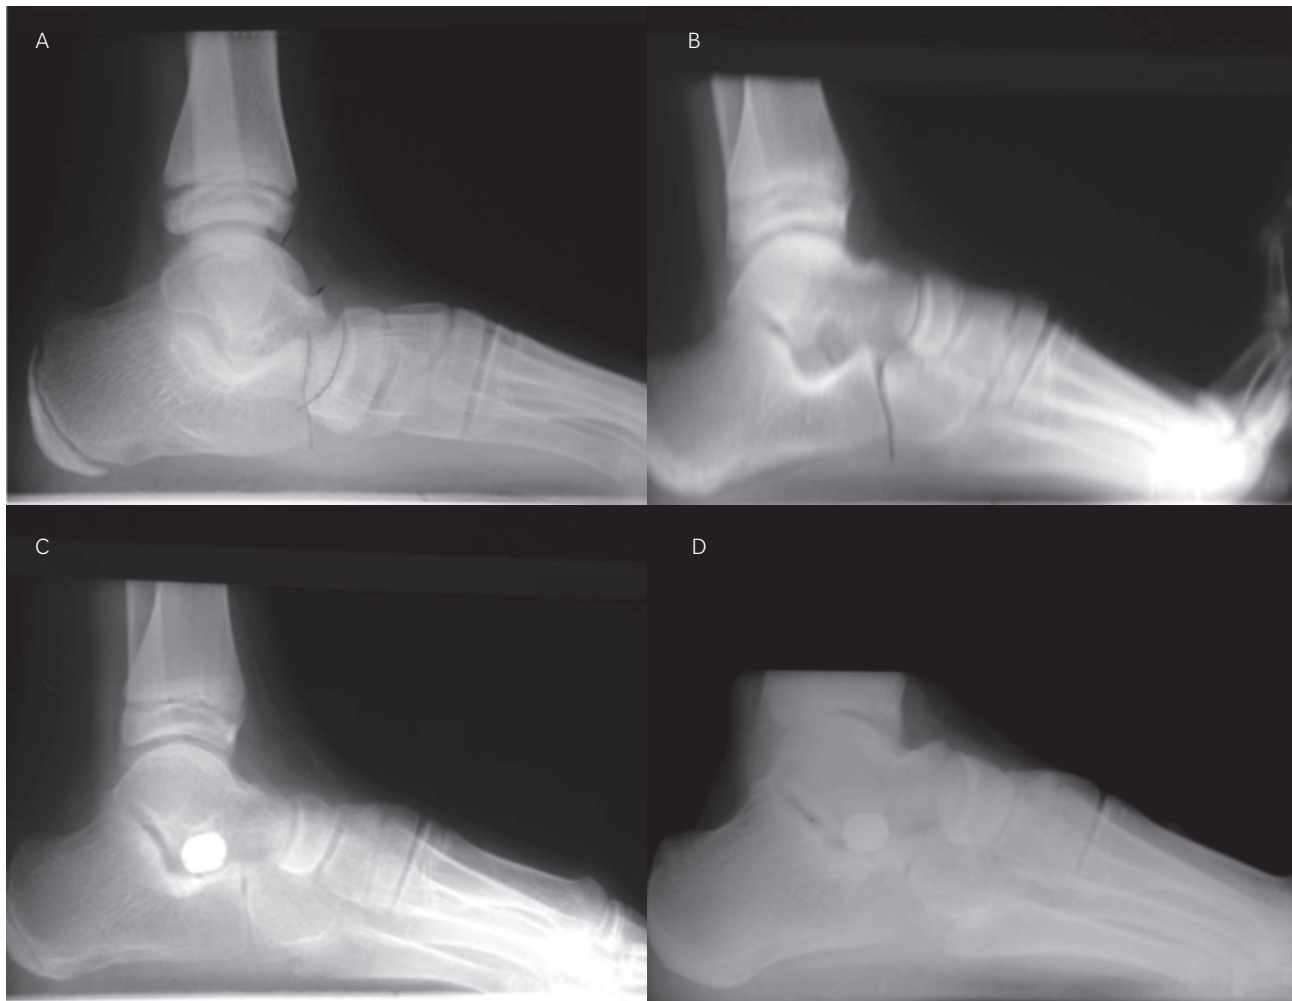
A. Preop lateral xray. B. Preop neutral position lateral xray. C. Postop lateral xray. D. Postop lateral xrays 6 years postop.
